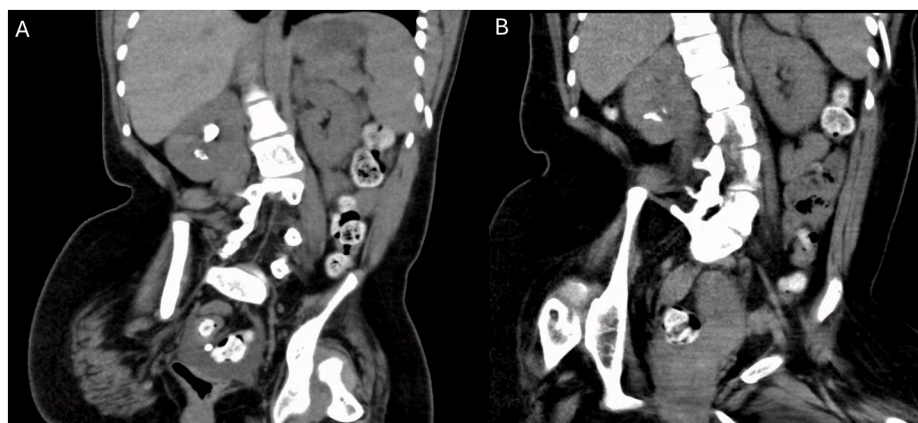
Visual comparison of scan quality between (A) standard-dose CT protocol (3.20 mSv), and (B) low-dose protocol (2.03 mSv). CT scan comparison is made between the same patient who underwent both CT scan protocols approximately 4 years between scans.
